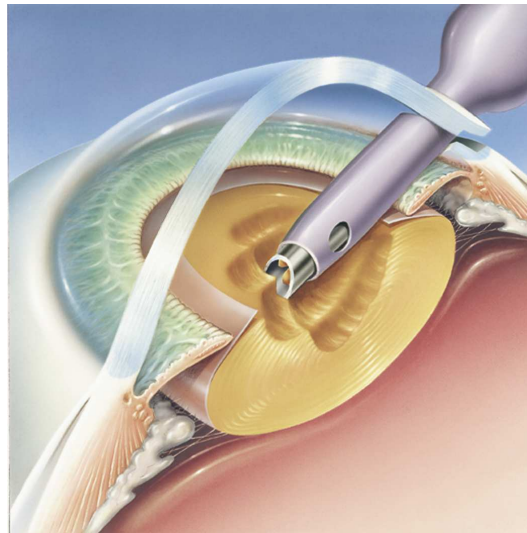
In phacoemulsification the eye's internal lens is emulsified utilizing an ultrasonic handpiece, and aspirated from the eye.
